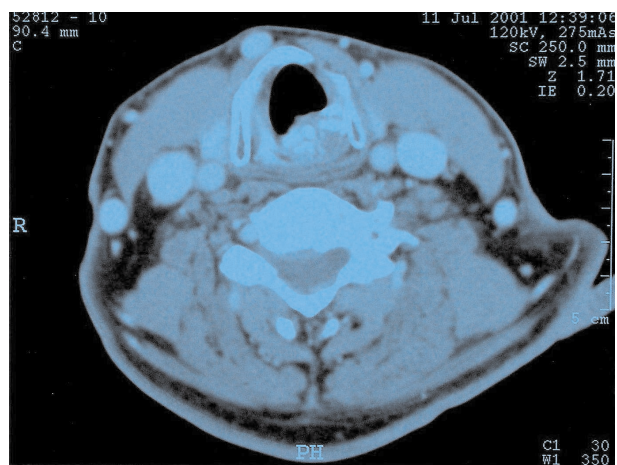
CT scan demonstrates tumor arising from lamina arch of the cricoid cartilage on the left
